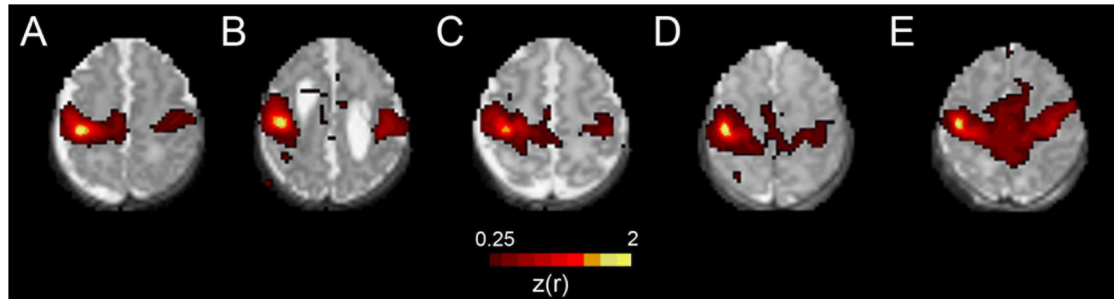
Effect of brain injury on functional connectivity in prematurely-born infants. Transverse views of the motor resting state network identified using resting state-functional MRI in representative, individual very preterm infants scanned at term equivalent postmenstrual age with A) grade IV intraventricular hemorrhage (note the asymmetric effect dependent upon hemisphere of injury), B) post-hemorrhagic hydrocephalus and C) cystic periventricular leukomalacia. Results from D) an uninjured very preterm infant and E) a healthy, term-born infant are provided for comparison. Note the differences in effects on resting state network development across each form of brain injury common in this clinical population.
